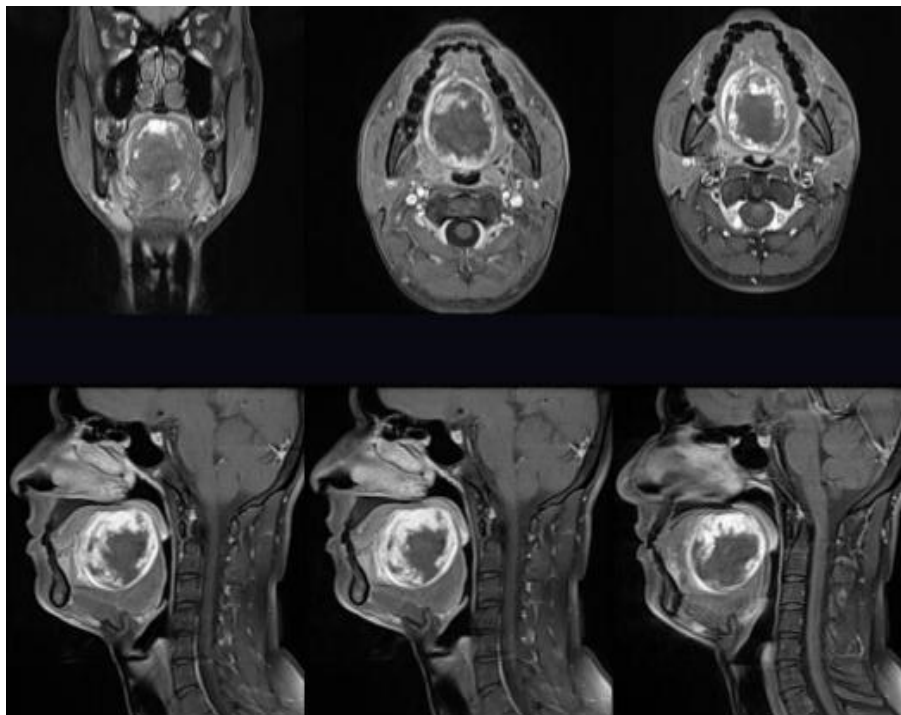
2. MRI revealed, a well-defined round to oval slightly lobulated heterogenous lesion in posterior part of tongue involving intrinsic muscles and superior portion of floor of mouth with intense peripheral enhancement, delayed filling, calcifications within as described above, mostly suggestive of slow flow venous malformation.
